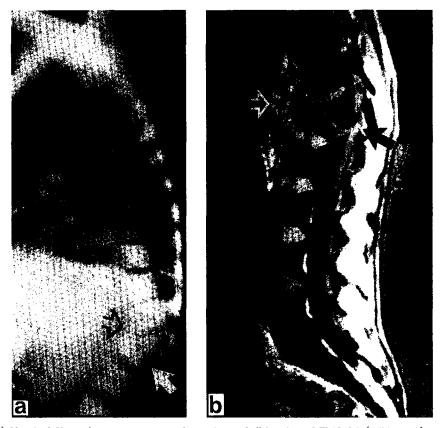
Case 1. (a) Vertebral X-ray demonstrates severe destruction and dislocation of Th12-L1 (solid arrow), resulting in kyphotic angulation (open arrow). (b) Sagittal T1-weighted MR image shows prevertebral soft tissue swelling (open arrow), imminent compression of the myelum in the kyphotic angulation (solid arrow), H-shaped vertebrae and diffuse low signal intensity of all vertebrae indicating active haematopoietic tissue.
